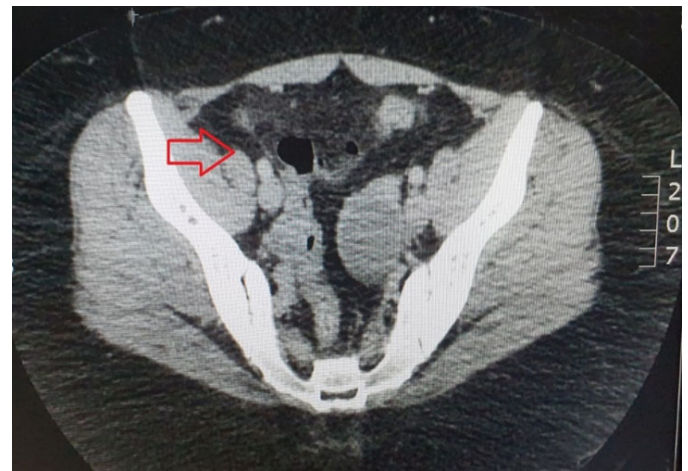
Axial CT scan: red arrow indicates the slightly dilated appendix at 6.3 cm with inflammatory changes in the distal ileum.
